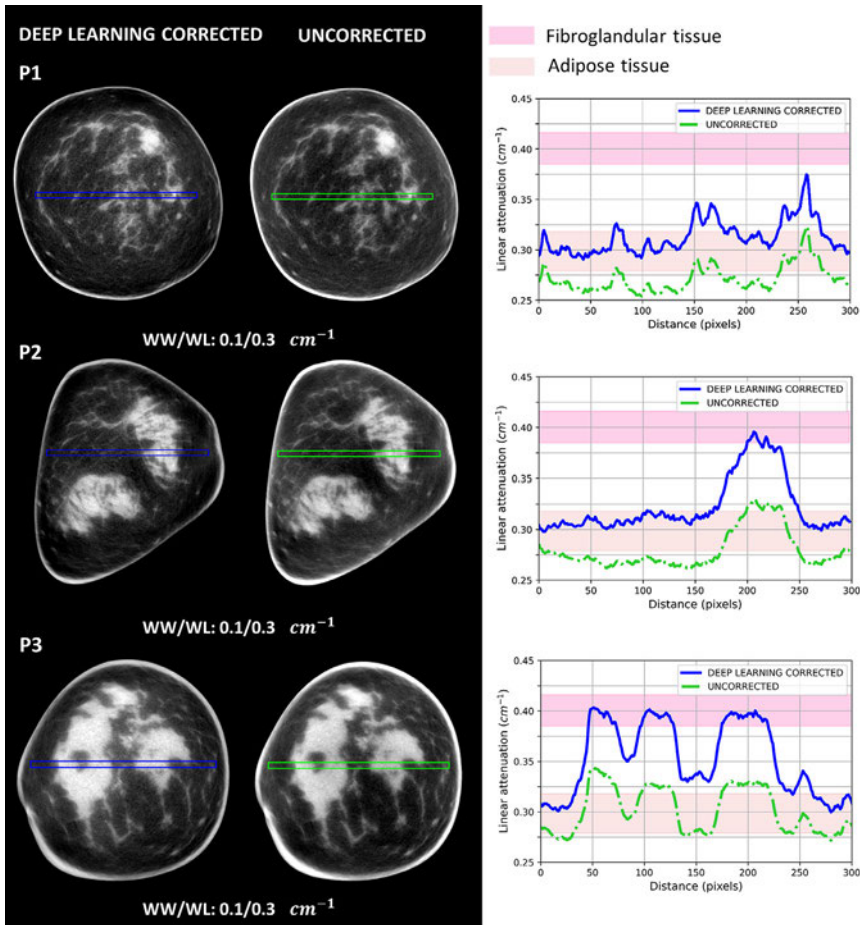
Example of profiles obtained for the three selected slices of reconstructed patient bCT images, both uncorrected and DL-corrected. The filled band represents the obtained range of x-ray linear attenuation values for fibroglandular (fuchsia) and adipose tissue (pink).
